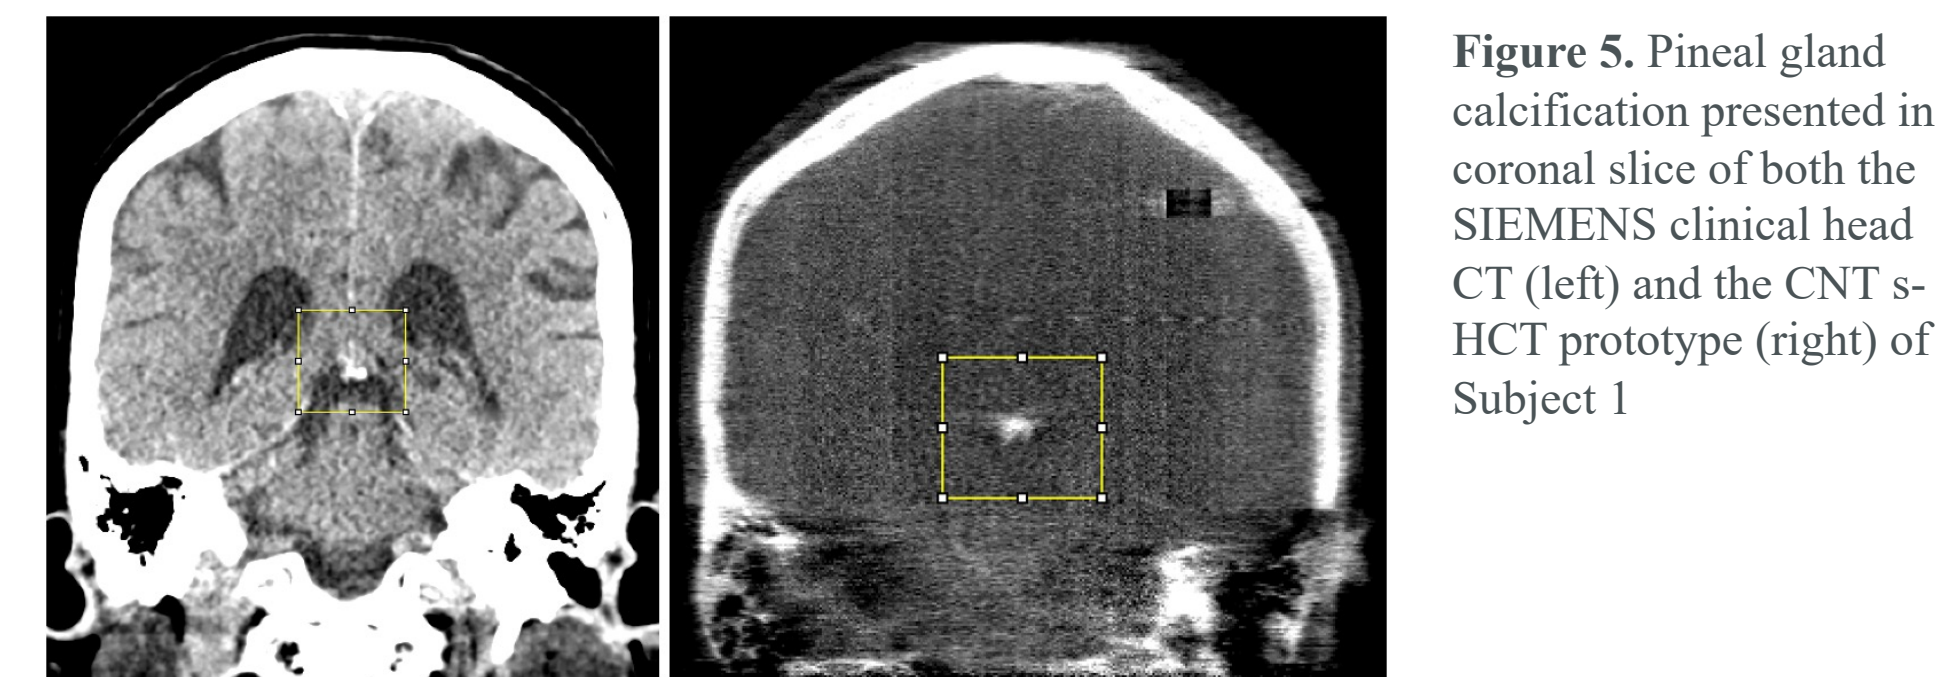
Pineal gland calcification presented in coronal slice of both the SIEMENS clinical head CT (left) and the CNT s-HCT prototype (right) of Subject 1
